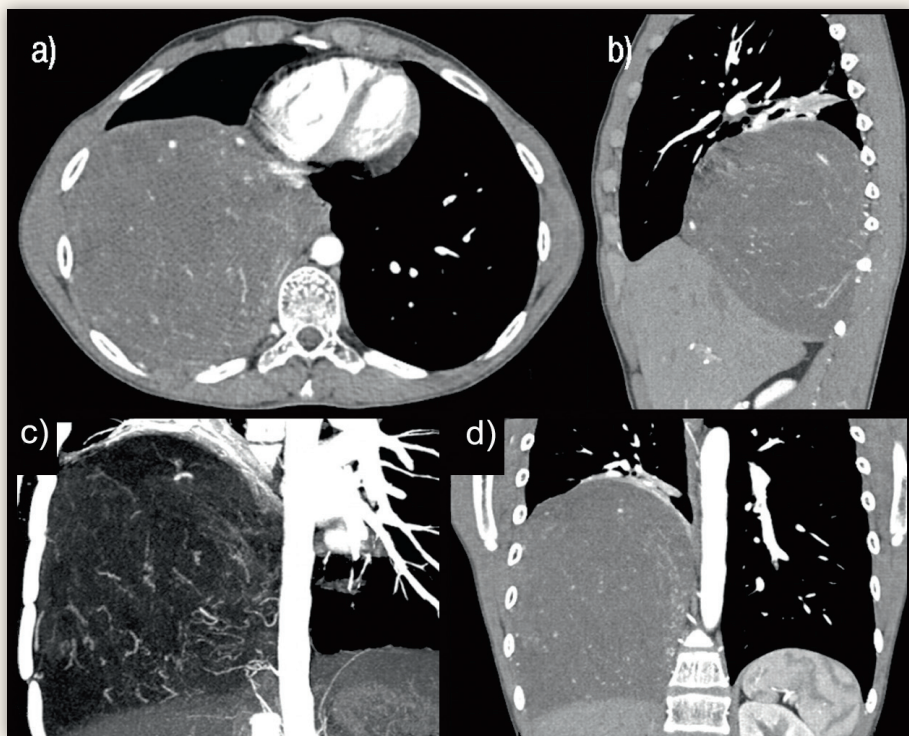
Computed tomography angiography of thorax and upper abdomen. Representative images are shown in a) transversal, b) sagittal, and c and d) frontal views. A computed MIP-reconstruction is shown in c.
